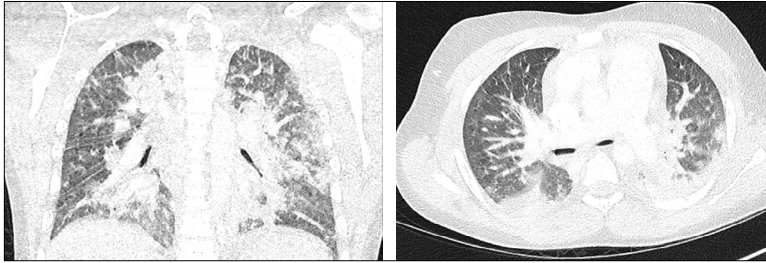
Lung window axial and coronal CT images of patient 3 that show diffuse bilateral consolidations predominantly located in the posterior aspects of the upper and inferior lobes
